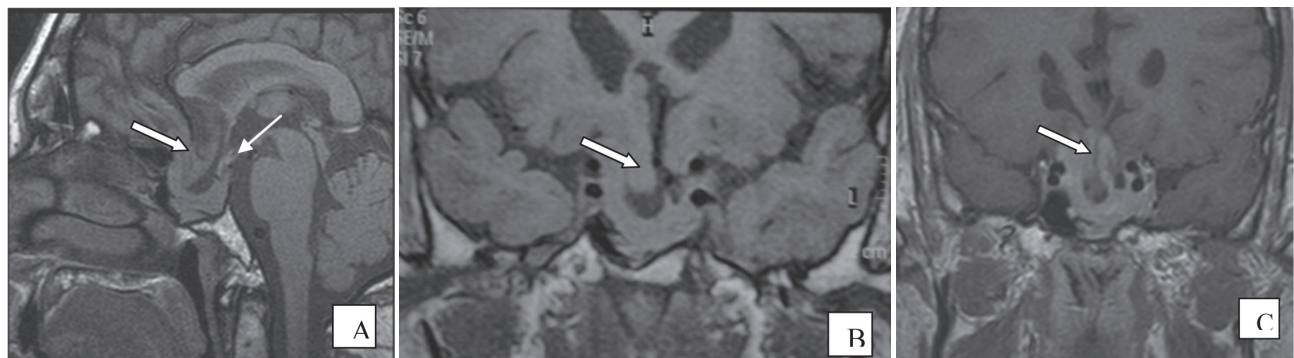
Pituitary T1-weighted images in sagittal (A) and coronal (B) and coronal after gadolinium enhancement (C) MRI scan, respectively, after 5 months under cabergoline treatment. Post-treatment figures depict a marked reduction of the tumor mass and a herniation of the inferior frontal lobe (thick arrow) and the optic chiasm (thin arrow) into the pituitary sella.
